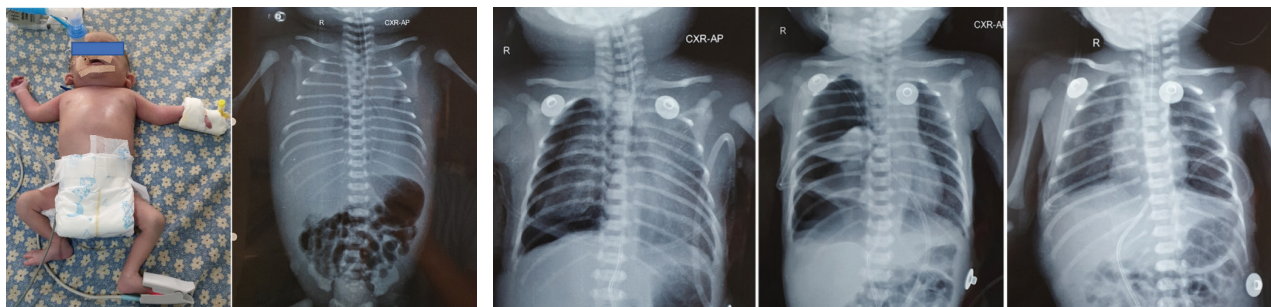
The first chest X-ray of the baby showing bilateral hydrothorax
